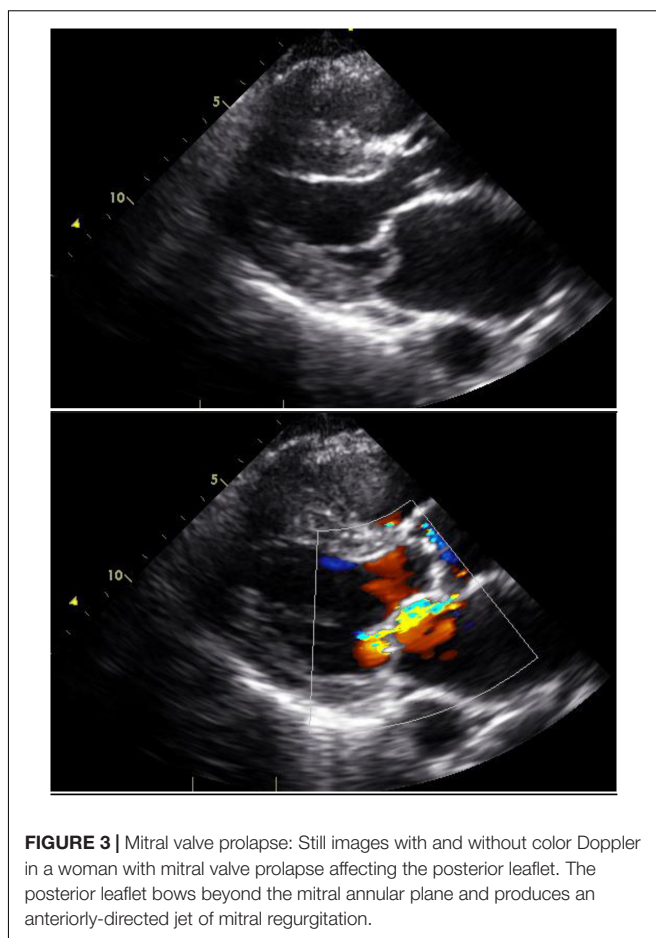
Mitral valve prolapse: Still images with and without color Doppler in a woman with mitral valve prolapse affecting the posterior leaflet. The posterior leaflet bows beyond the mitral annular plane and produces an anteriorly-directed jet of mitral regurgitation.
